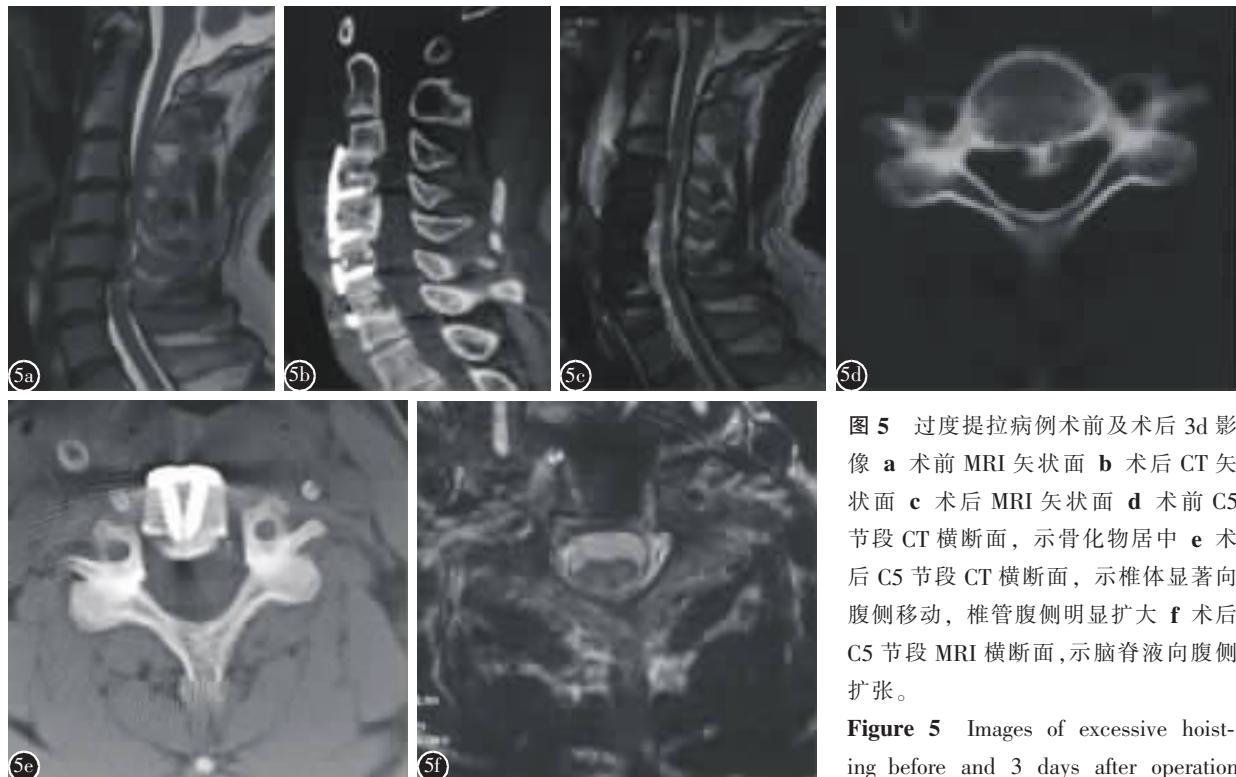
过度提拉病例术前及术后 3d 影像 a 术前 MRI 矢状面 b 术后 CT 矢状面 c 术后 MRI 矢状面 d 术前 C5 节段 CT 横断面, 示骨化物居中 e 术后 C5 节段 CT 横断面, 示椎体显著向腹侧移动, 椎管腹侧明显扩大 f 术后 C5 节段 MRI 横断面, 示脑脊液向腹侧扩张。
